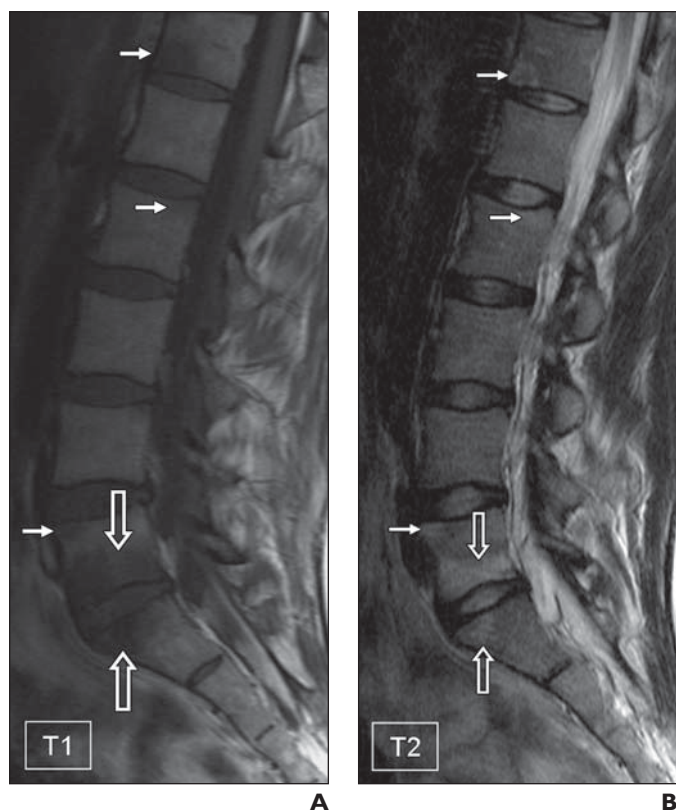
29-year-old woman with spondyloarthritis. A and B, Sagittal T1-weighted (A) and T2-weighted (B) MR images of lumbar spine show bone marrow edema (B) of cortical plate adjacent to L5-S1 intervertebral disk representing Andersson lesion (open arrows) and spondylitis of anterior and posterior vertebral corners (solid arrows).
